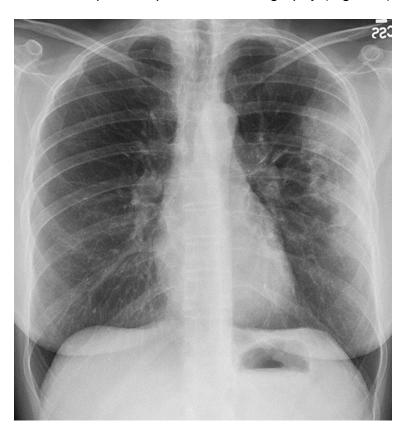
Repeat frontal chest radiography.
